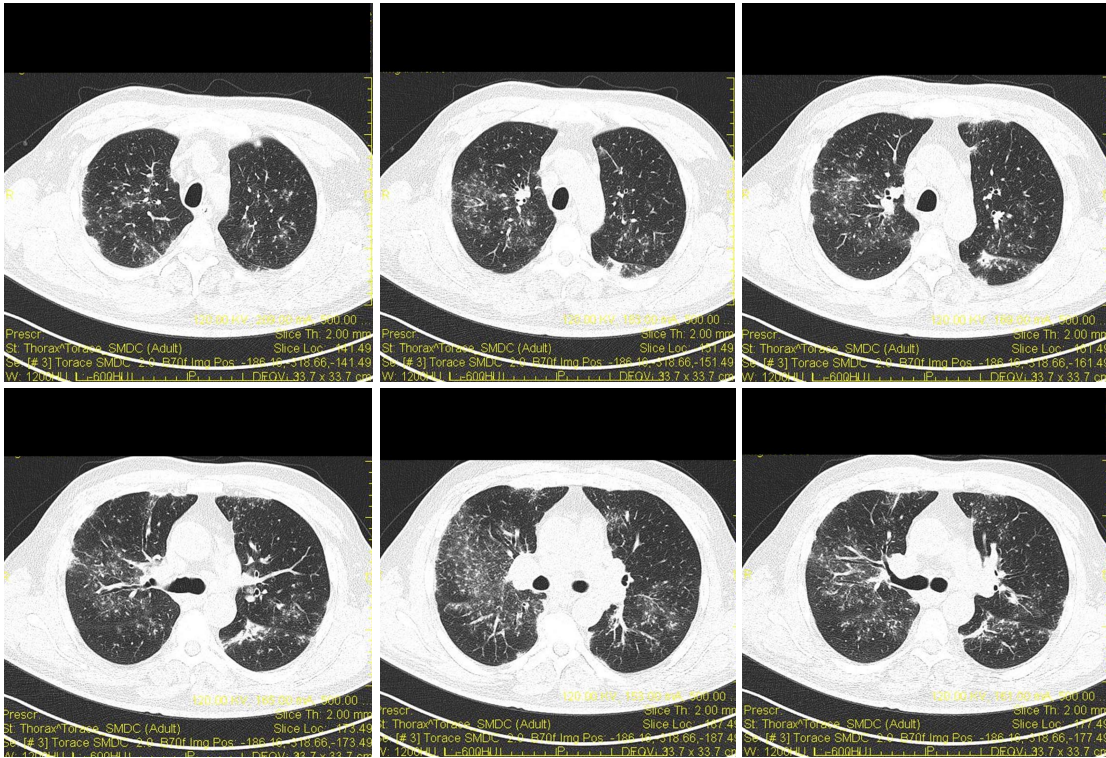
Pulmonary computed tomography.
